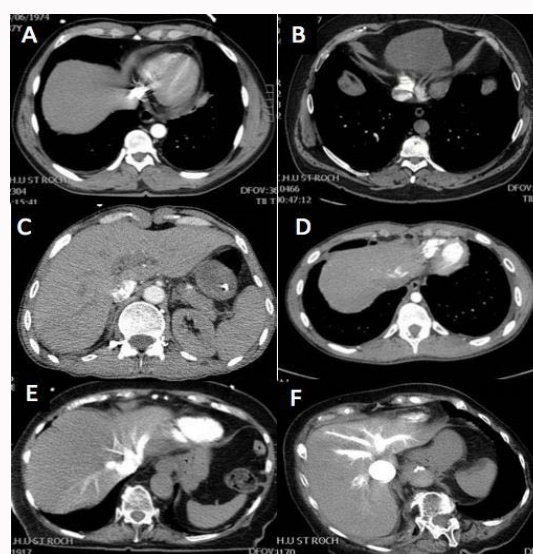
Axial CT pulmonary angiography sections through the liver showing varying degrees of intravenous contrast reflux into Inferior Vena Cava (IVC) and hepatic veins (HV). A.B.C: No or trivial RC. D.E.F: Major RC.
